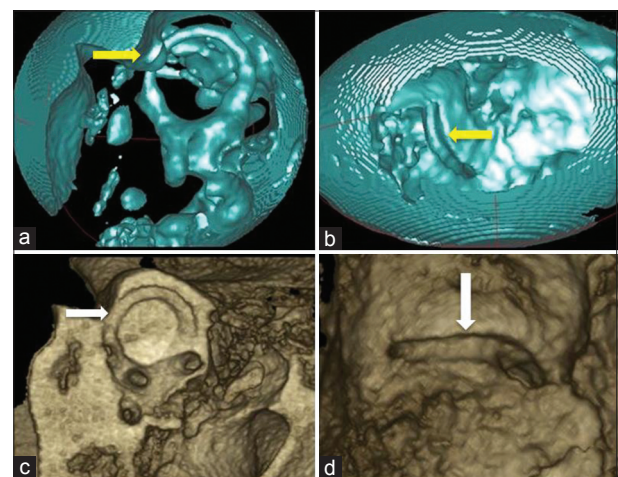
17-year-old patient with clinic history of progressive hearing loss, without vertigo and oscillopsia diagnosed with sensorineural hearing loss and right superior semicircular canal dehiscence. CBCT of temporal bone, air cavity volume rendering (green) images (a) sagittal view, (b) endocranial view, (c) osseous volume rendering oblique sagittal view and (d) osseous volume rendering superior view show superior semicircular canal dehiscence (yellow arrow in a), (yellow arrow in b), (white arrow in c), and (white arrow in d).
